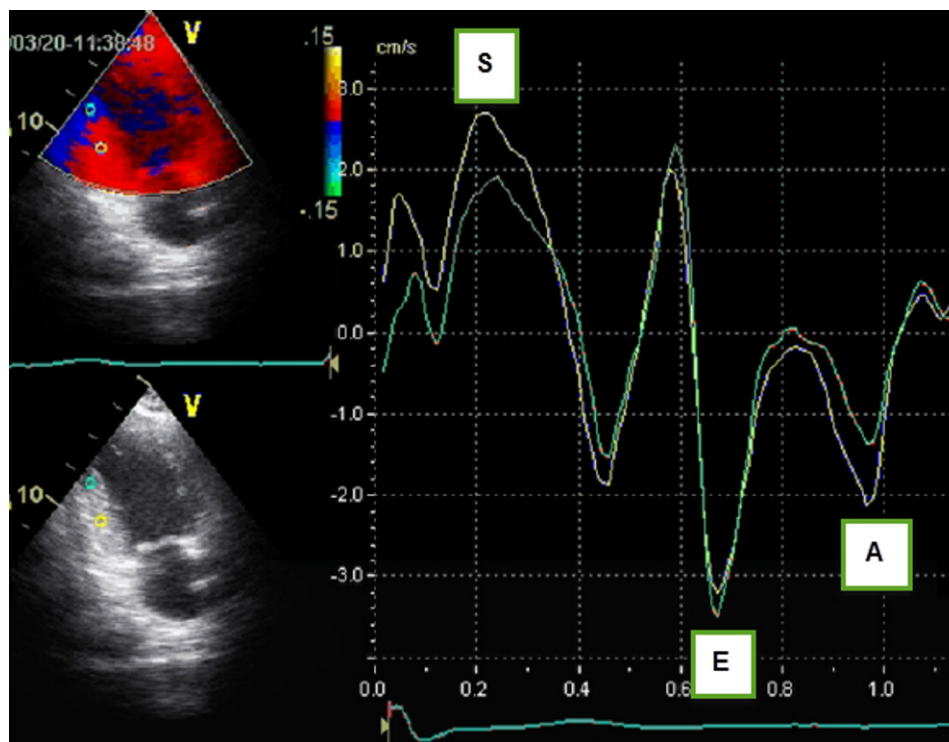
Tissue Doppler image at the level of the mitral annulus. A — atrial contraction induced velocity wave of the mitral annulus; E — velocity wave following early filling; S — systolic velocity wave, following contraction of the left ventricle
